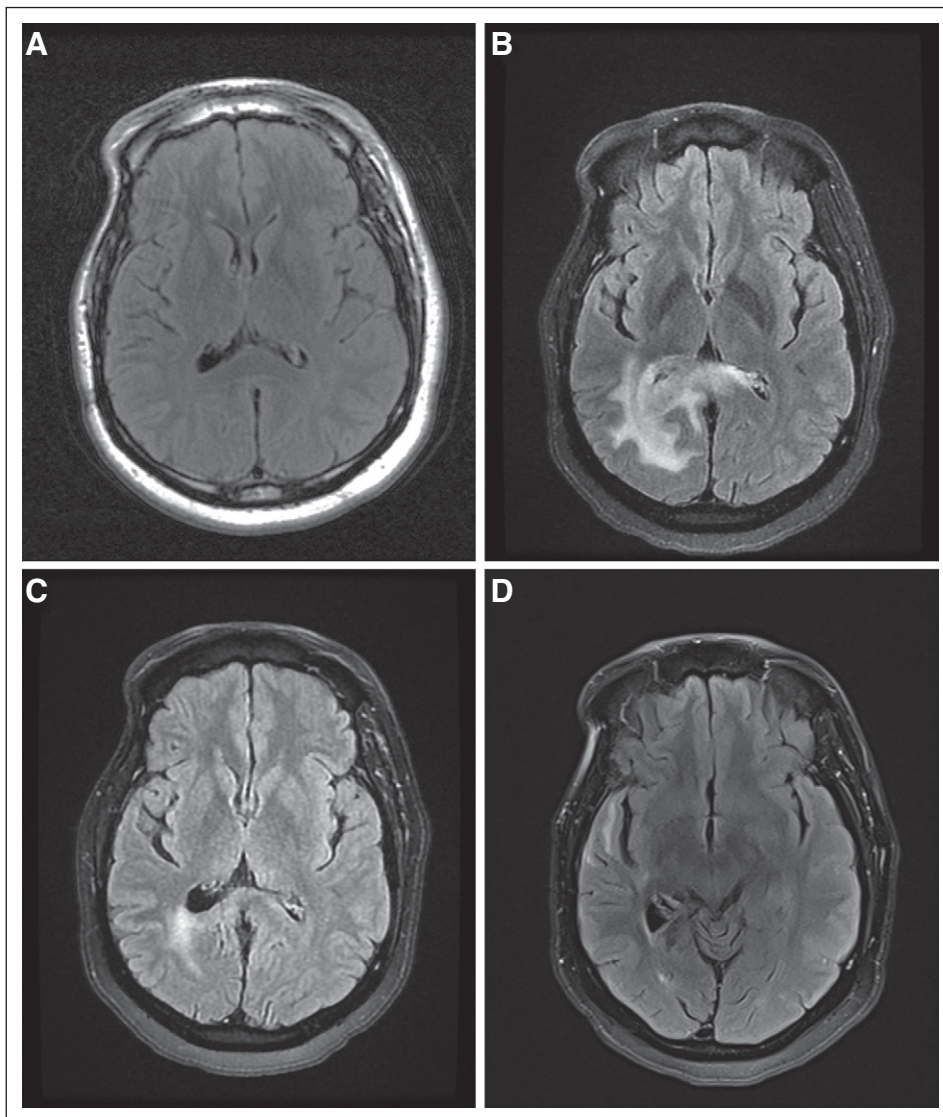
Axial T2-weighted magnetic resonance imaging scans from a patient who developed cerebral radiation necrosis 18 months after gross total resection and adjuvant radiation for treatment of anaplastic astrocytoma. (A) Surveillance imaging showed postoperative gliosis with no evidence of radiation necrosis. (B) Surveillance magnetic resonance imaging revealed abnormal white matter signal in the right temporal lobe with extension across midline. (C). Radiation necrosis was confirmed with biopsy and images obtained after 32 and (D) 60 treatments with hyperbaric oxygen monotherapy showed marked radiologic improvement.
